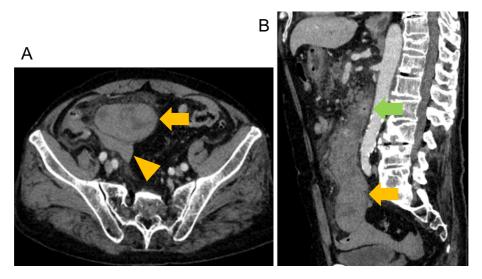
A: Computed tomography images showing a heterogeneous mass in the abdomen (yellow arrow). High-density fluid is also observed (arrowhead). B: The cranial part of the mass is approaching the inferior wall of the duodenum (green arrow).
